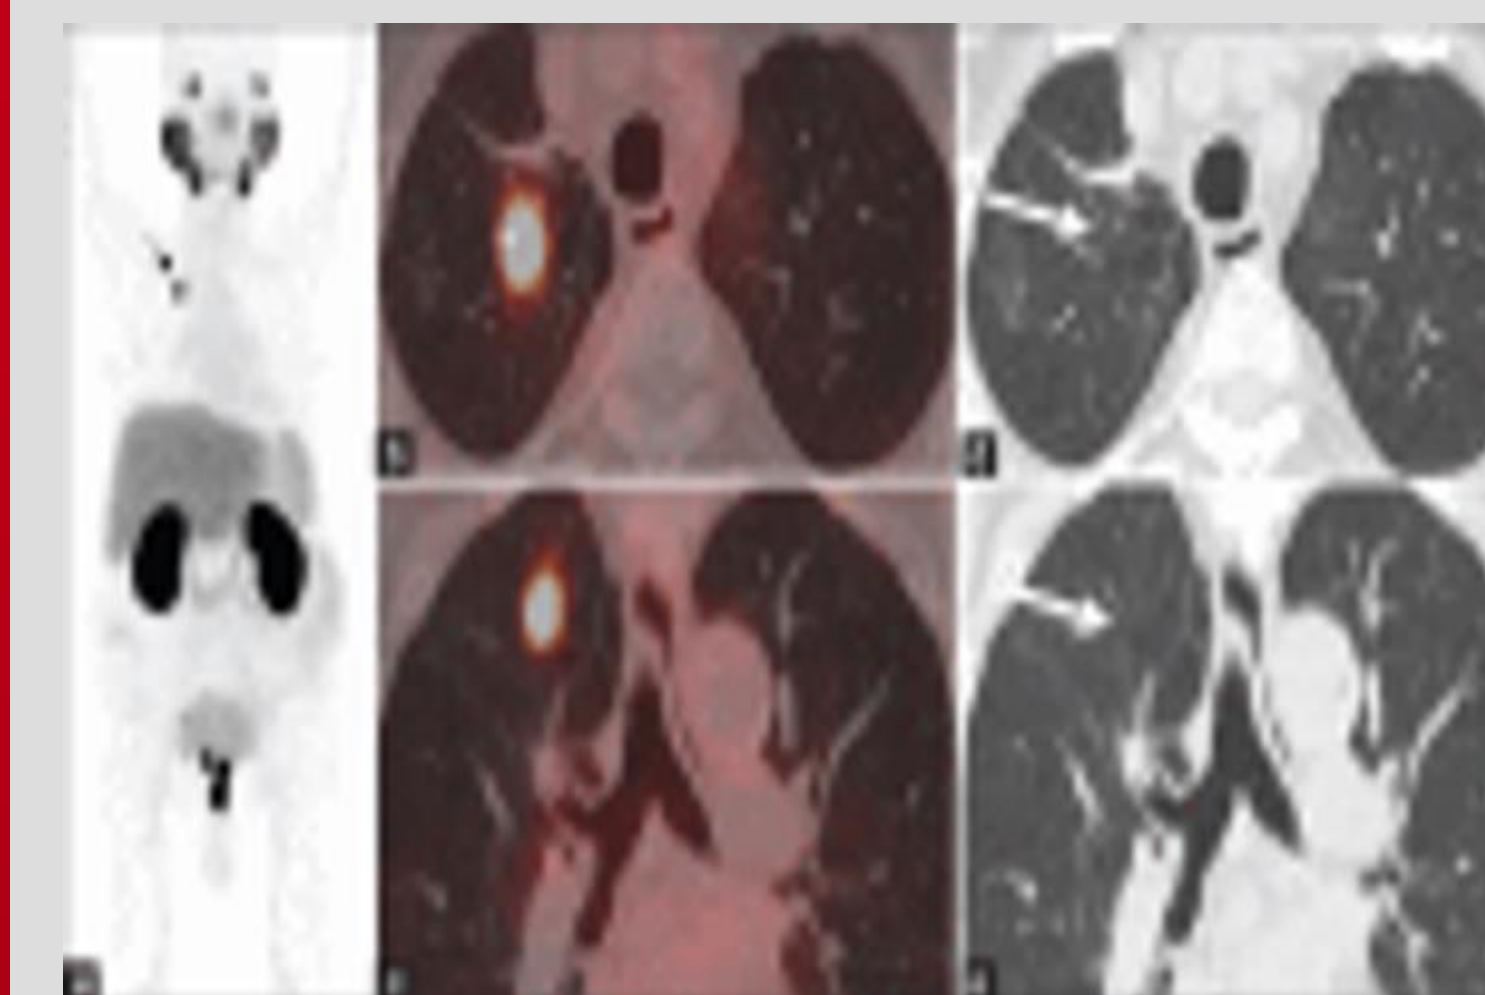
PSMA Pulmonary Radiotracer Embolus
